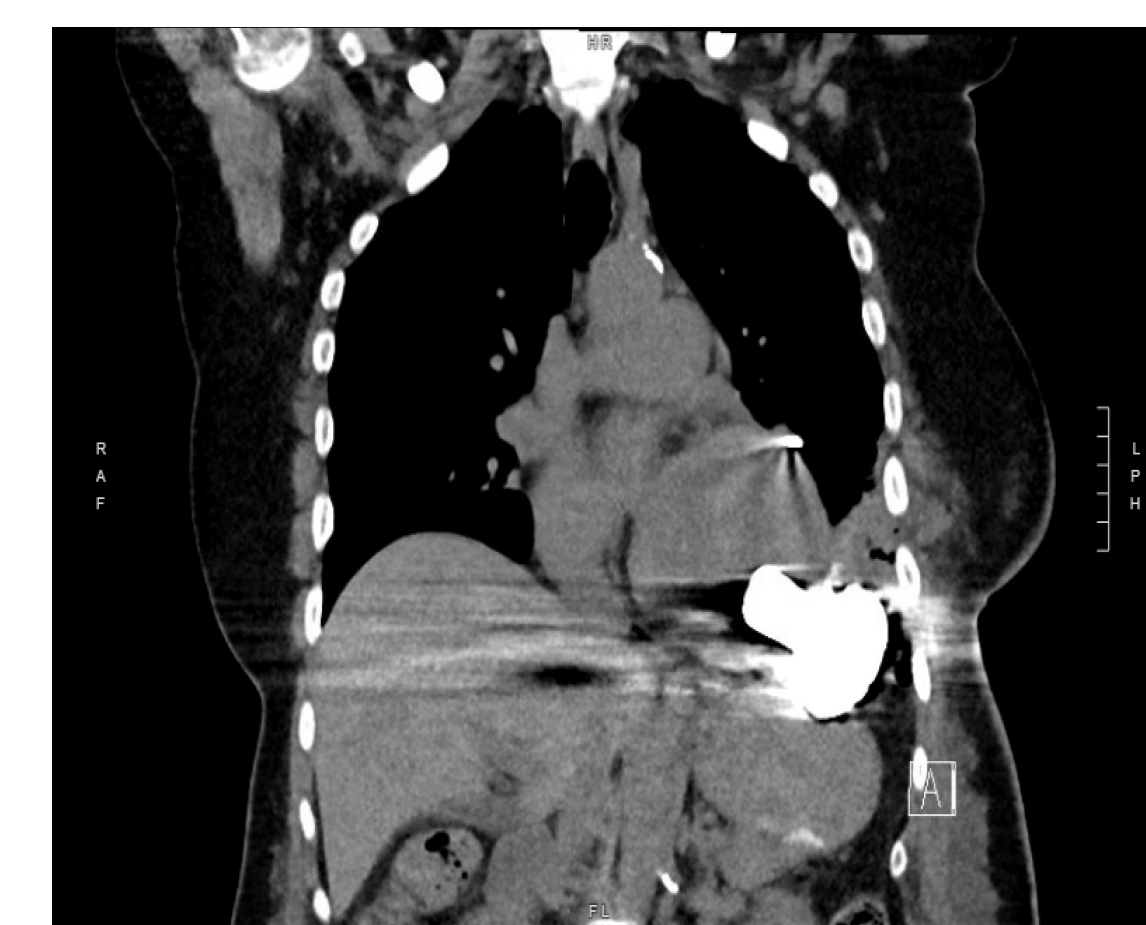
CT one month post-surgery with stable position of the LVAD
